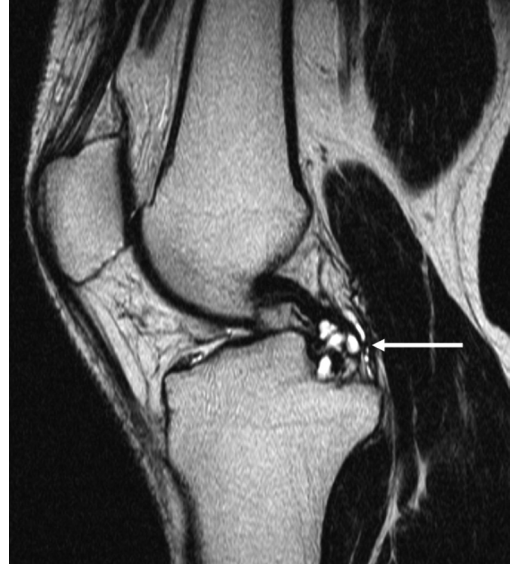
PCL ganglion. Sagittal T2-weighted turbo spin echo image. A well-defined globular lesion with high signal intensity is seen surrounding the distal portion of the PCL (arrow), representing a ganglion of the PCL.
